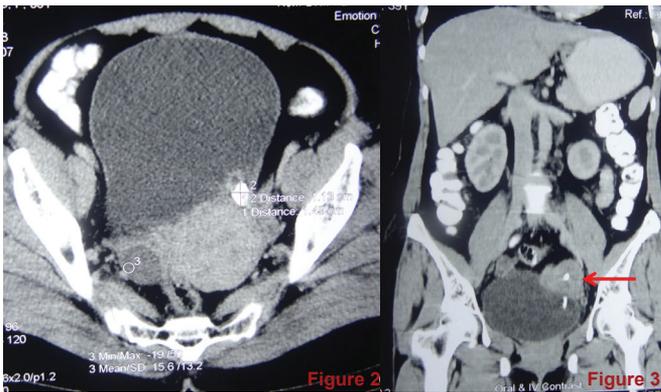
Axial CT scan showing heterogenous lesion in the left adnexa of uterus
